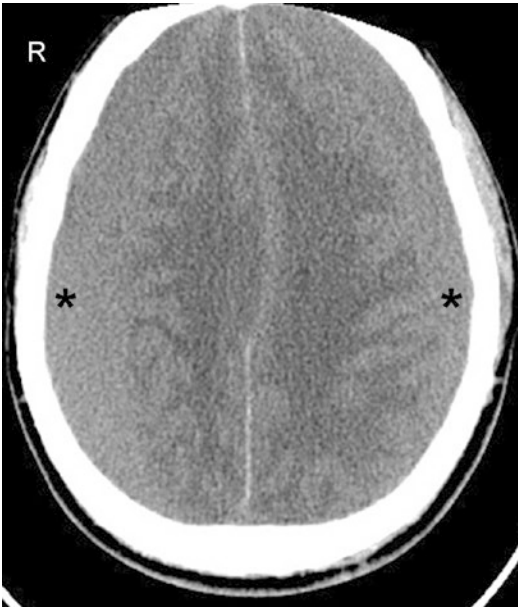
Isodense subacute SDH. Non-contrast axial CT image shows bilateral isodense SDHs. During the transition from acute to chronic SDH, an isodense phase occurs. At this stage, the SDH (*asterisk*) can be difficult to differentiate from the adjacent brain parenchyma. Note displacement of the gray-white matter junction from the inner table of the skull (the “thick gray matter mantle” sign)
